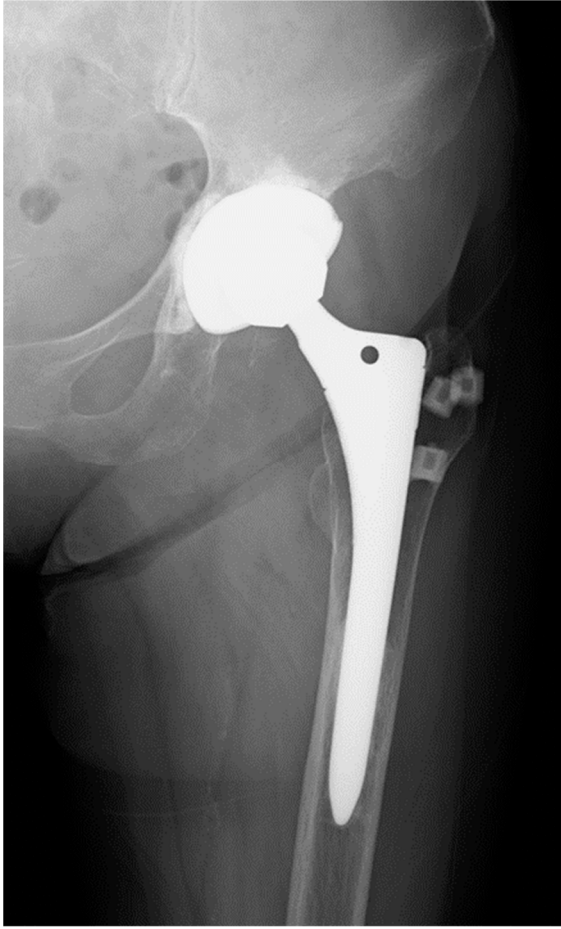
Radiographs of the left hip of a 74-year-old woman.
